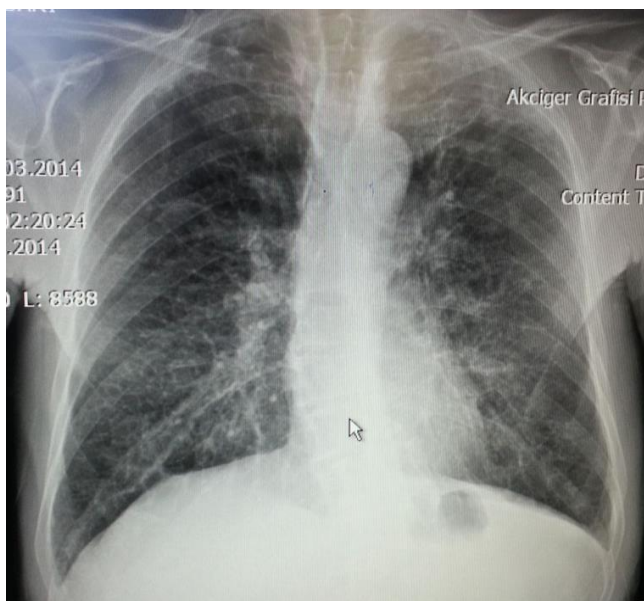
Admission PA chest x-ray of the patient was consistent with emphysema
